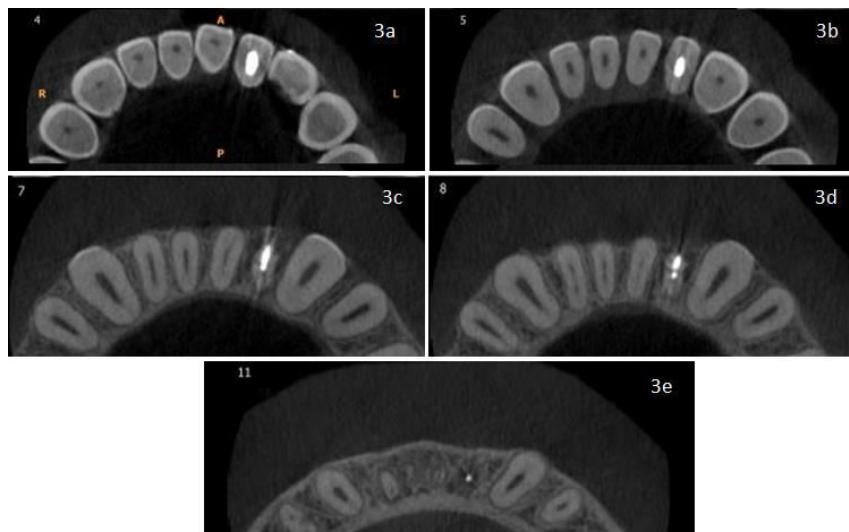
Axial CBCT images shows minimal resorption in 3a and 3b but as we move down apically (3c and 3d) replacement resorption is evident in buccal and proximal aspect and the last axial section apically (3e) shows only gutta-percha remnants completely embedded in substituted bone.
